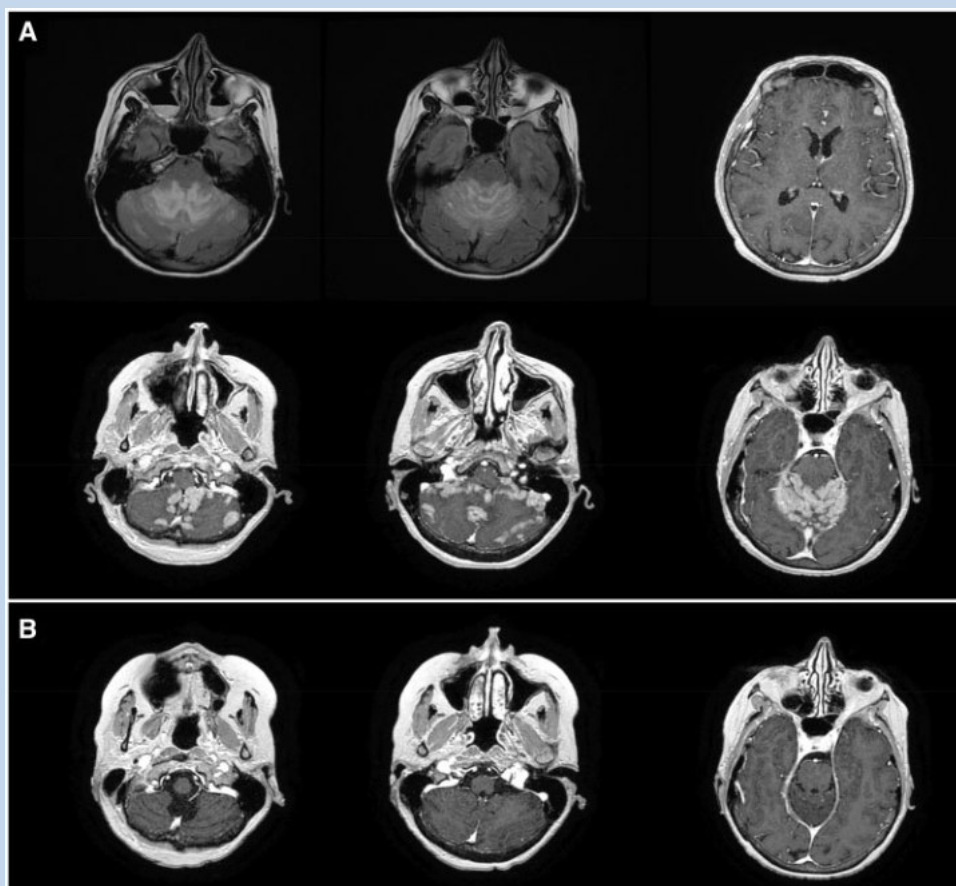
(A) Brain MRI (gadolinium T1-weighted and FLAIR-weighted) at the diagnosis of leptomeningeal metastases showing large confluent leptomeningeal enhancing nodules located within the vermis and cerebellar hemispheres, and a smaller leptomeningeal nodule within the left frontal lobe; (B) brain MRI after the completion of whole brain radiation therapy, 5 administrations of intrathecal methotrexate and one cycle of Capecitabine-Lapatinib, showing a complete regression of the leptomeningeal nodules within the posterior fossa.
